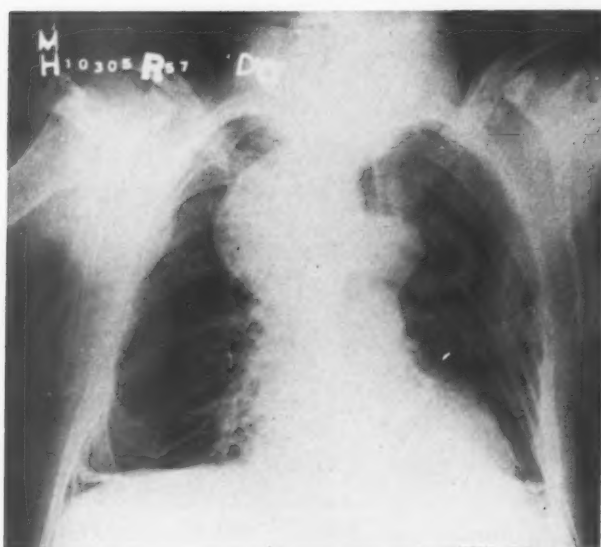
Roentgenogram of the chest taken on February 25, 1957, again showing the mediastinal mass, unchanged except for the presence of a thin rim of calcification.
